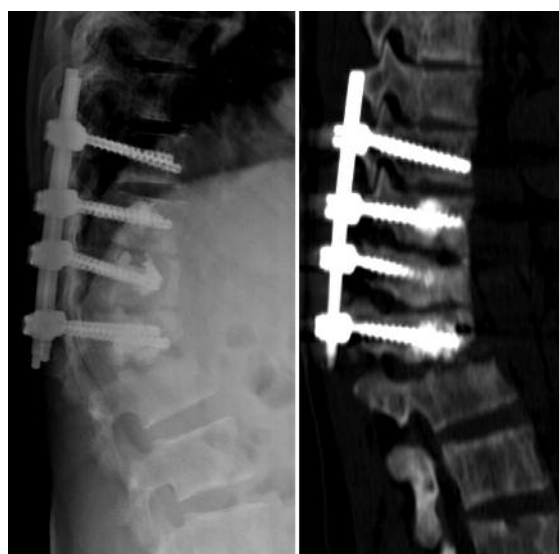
Lateral X-ray and sagittal CT scan performed four months after the first surgery, showing L1 fracture.
